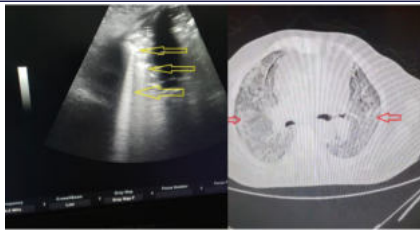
Lung ultrasound and CT thorax image of a severe COVID-19 patient: pleural line irregularity with subpleural consolidations (yellow arrows), bilateral ground glass opacity noted in the CT scan (red arrows)
